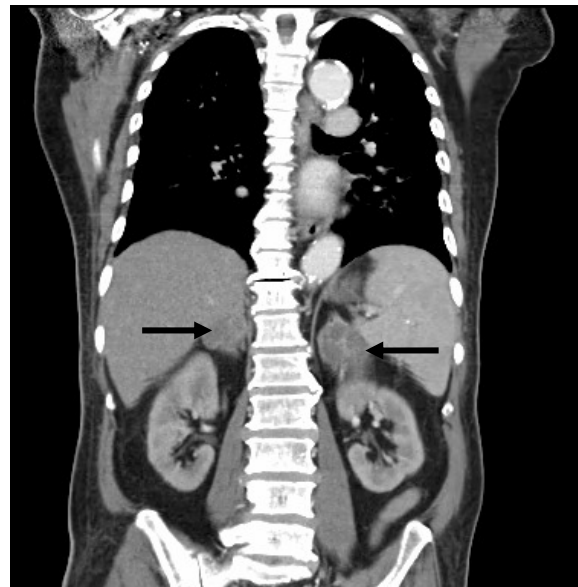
Sagittal computed tomography scan showed heterogenous enhancing bilateral adrenal enlargement (arrow).
